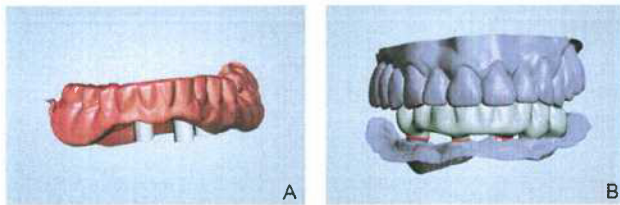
A, STL model of CBCT digitized denture combined with extension of planned implants. B, Gingivally reduced interim implant-supported prosthesis. CBCT, cone beam computed tomography; STL, standard tessellation language.
